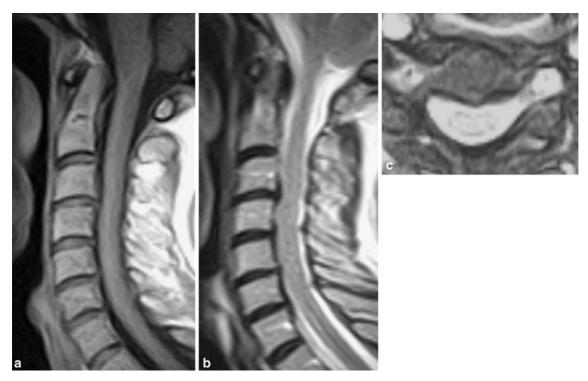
MRI 1 month later: disappearance of the haematoma
